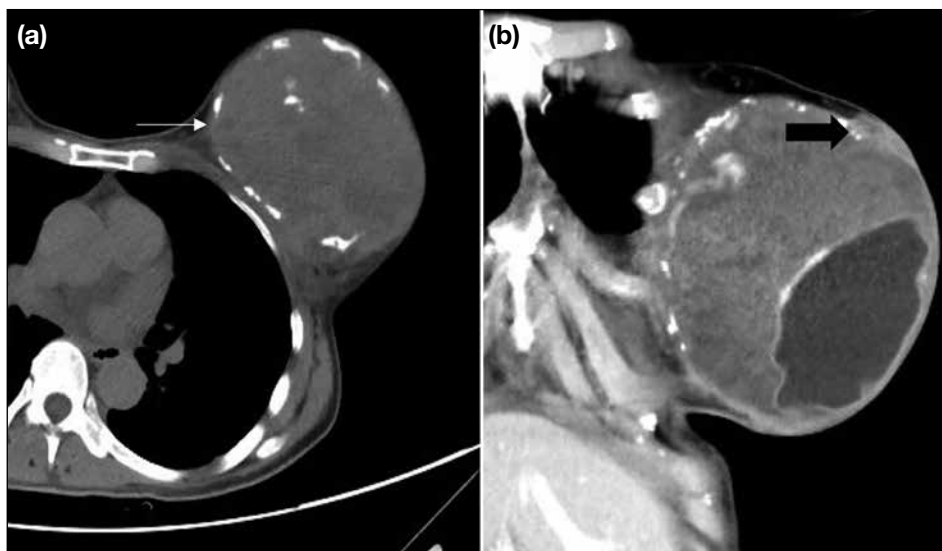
Angiosarcoma. Computed tomography scan of the thorax. (a) The left breast implant capsule (arrow) is seen adjacent to a heterogeneous soft tissue mass with (b) predominantly peripheral enhancement (arrow).
